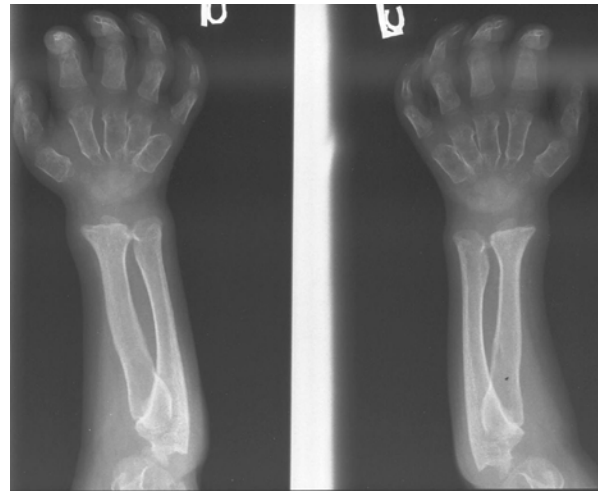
Rapidly progressing 7-year old female MPS VI patient: radiograph of hand. Typical radiological findings of MPS VI include thickened, short metacarpal bones with proximal pointing and thin cortices, carpal bones that are irregular and hypoplastic, V-shaped deformity of ulna and radius.
